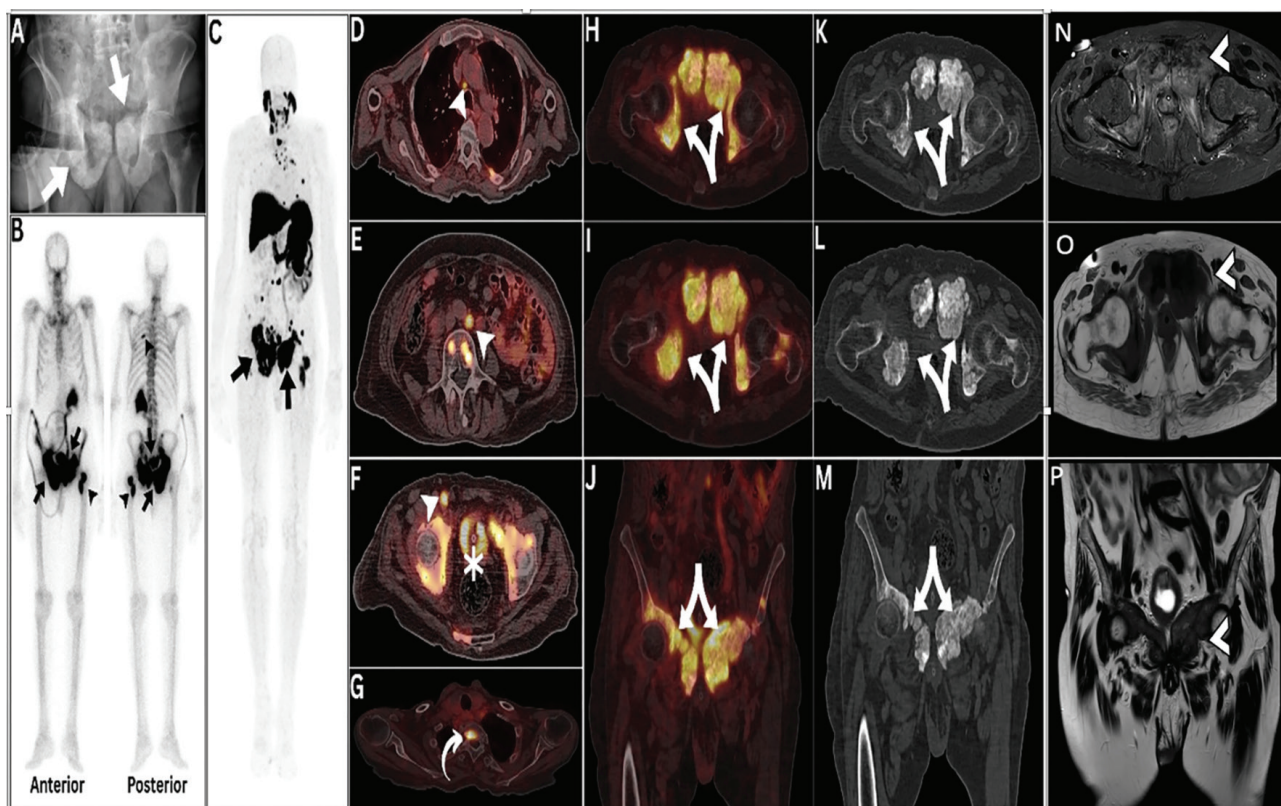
A 70-year-old man with metastatic hormone-sensitive prostate adenocarcinoma, treated with abiraterone and goserelin, developed progressive bilateral pubic pain. The patient provided written informed consent. Lab studies showed significantly elevated prostate-specific antigen and alkaline phosphatase levels. Pelvic X-ray revealed bony expansion with increased bone density and thickened cortex in both pubic bones (A, pelvic radiograph; arrows), which corresponded to an area of increased radiotracer uptake on skeletal scintigraphy (B, anterior and posterior planar skeletal scintigraphy; arrows). Other radiotracer-avid bone lesions were noted on skeletal scintigraphy, raising suspicion for new-onset skeletal metastases (B, anterior and posterior planar skeletal scintigraphy; arrowheads). ⁶⁸Ga-prostate-specific membrane antigen positron emission tomography/computed tomography (⁶⁸Ga-PSMA PET/CT), revealed diffuse ⁶⁸Ga-PSMA-avid prostatic involvement, and extensive ⁶⁸Ga-PSMA-avid lymphadenopathy and bone involvement [C, maximum intensity projection (MIP) PET image, D-G, axial fused images; annotations]. The pubic bones, which corresponded to areas of severe pain, displayed pronounced hyperostosis and a “dripping candlewax” sign consistent with melorheostosis; they also showed intense ⁶⁸Ga-PSMA uptake, with a maximum standardized uptake value of 20.2 (C, MIP PET image; H-J, axial and coronal fused PET/CT images; K-M, axial and coronal CT images; arrows). Magnetic resonance imaging further characterized these lesions (arrowheads), demonstrating bilateral cortical and subcortical hyperostosis of the pubic bones with uniformly low signal intensity on T1-weighted images (O) and predominantly low signal intensity on T2-weighted images (P), consistent with dense sclerotic bone. STIR sequences (N) revealed superimposed hyperintensity of the marrow and adjacent soft tissues, indicating associated edema and suggesting metabolically active disease. The patient was diagnosed with metastatic castration-resistant prostate cancer, was started on taxane chemotherapy, and received symptomatic therapy for melorheostosis, which led to rapid relief of pubic bone pain.
